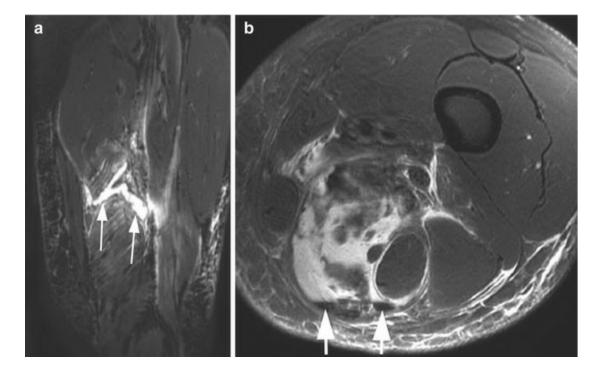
Complete tear of the semimembranosus muscle with minor retraction and hemorrhage. (a) Coronal proton density-weighted fat-suppressed MRI shows linear hematoma and complete disruption of the muscle belly (arrows). (b) Axial proton density-weighted fat-suppressed MRI shows extent of hematoma involving the whole cross-sectional area of the muscle and sedimentation within the hematoma characterized by susceptibility artifacts (arrowheads)
